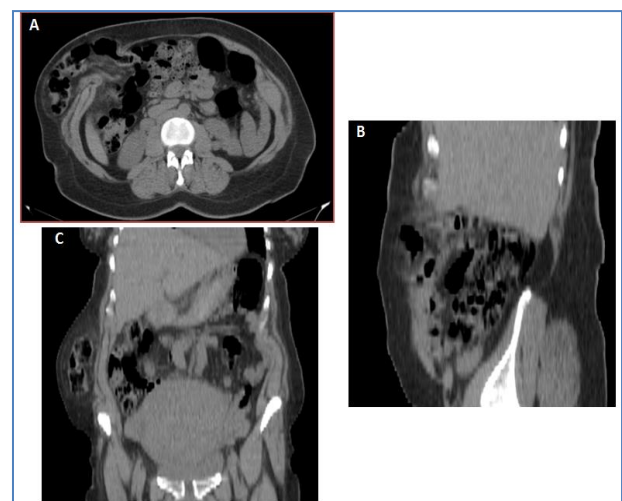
axial (A), sagittal (B) and coronal (C) non enhanced abdominal CT showing dehiscence on the right semilunar line, hernia sac with colonic and omentum contents
